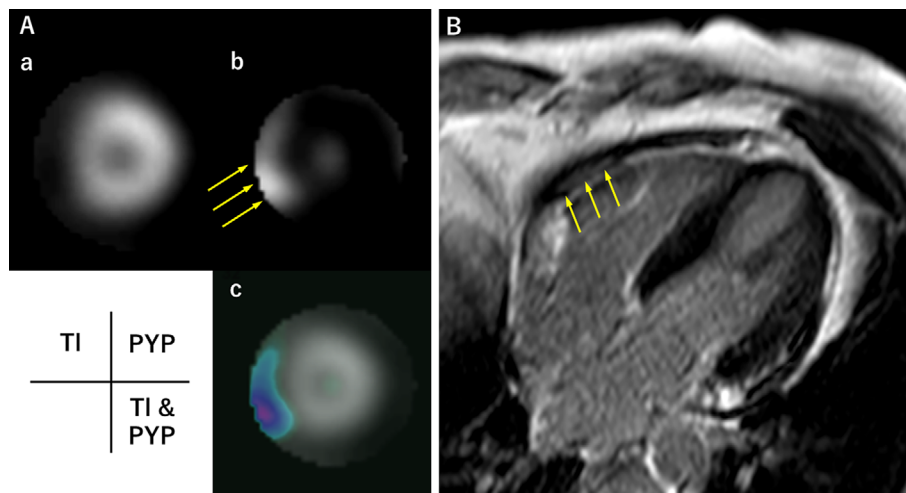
Thallium/pyrophosphate (TI/PYP) dual scintigrams and cardiac magnetic resonance imaging. (A) (a) The TI/PYP dual scintigrams were performed after three days. The TI scintigram showed no perfusion defect in LV. (b) The PYP scintigram showed the PYP accumulation only in the RV free wall (yellow arrows). (c) This image is the combination of TI and PYP scintigrams. (B) Cardiac magnetic resonance after five days revealed delayed enhancement in a part of the RV free wall (yellow arrows).
